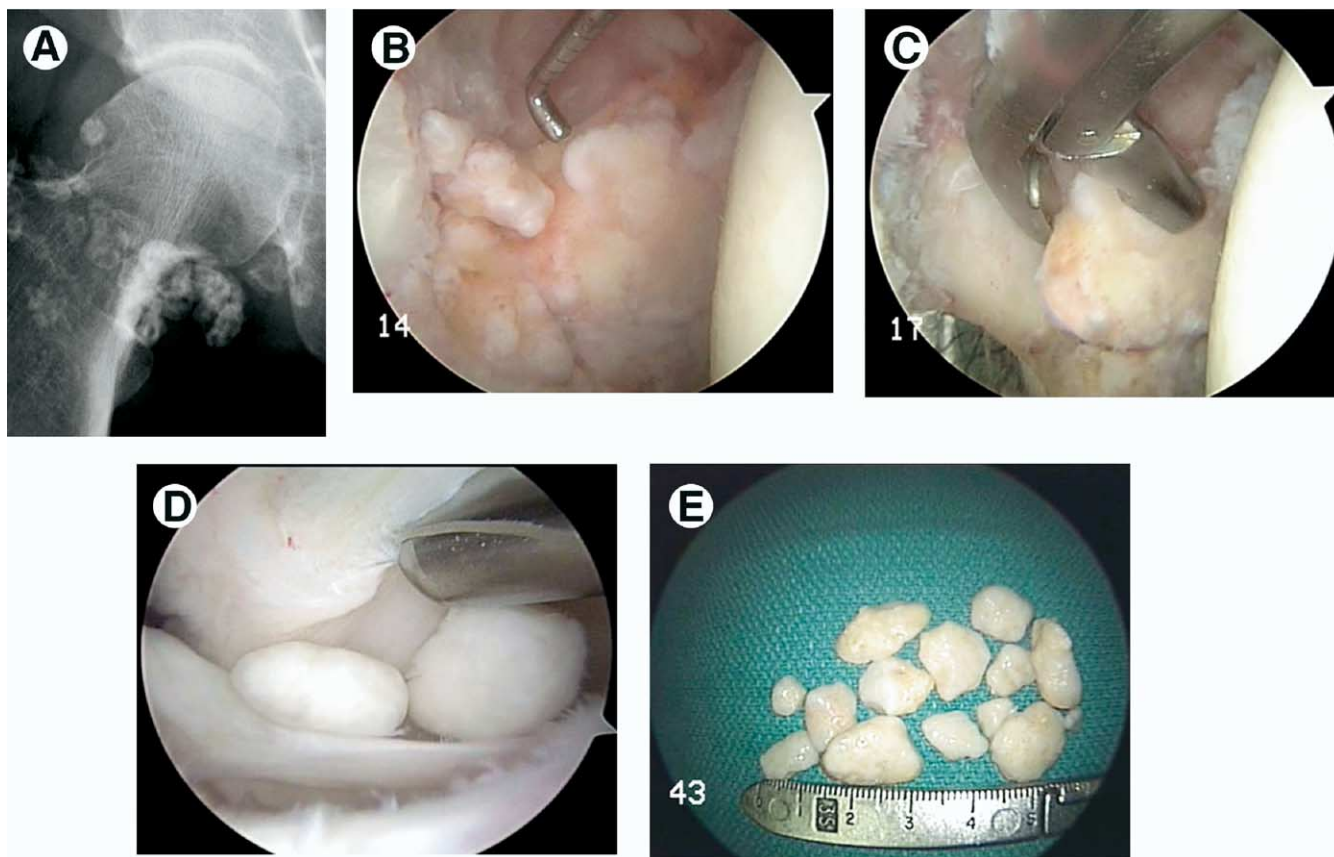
A 54-year-old Hall of Fame baseball player with a several-year history of insidious onset, progressively worsening mechanical right hip pain. (A) An AP radiograph shows evidence of synovial chondromatosis as well as secondary degenerative changes. (B) Arthroscopic view of the intra-articular compartment shows numerous lesions obliterating the acetabular fossa. (C) These are morselized and excised. (D) The peripheral compartment reveals more free-floating loose bodies. (E) Whole fragments removed from the peripheral compartment. (Figure © J.W. Thomas Byrd.) (Color version of figure is available online.)
